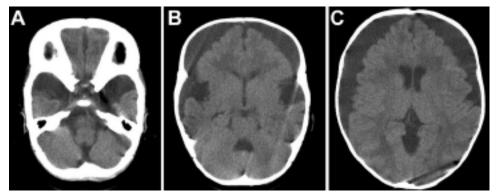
Computed tomography scans demonstrating subdural collections in the middle cranial fossa (A), bilateral prominent opercular cisterns (B), and large bilateral chronic SDHs (C) causing moderate underlying mass effect.
